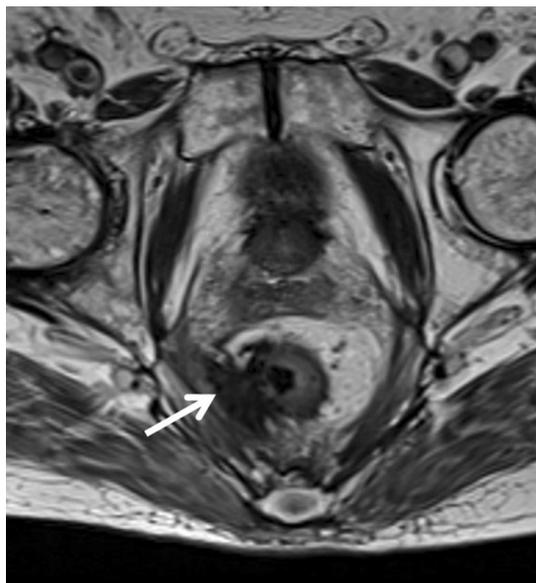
Recurrent tumor after TAMIS. A 72-year-old man. Axial T2-weighted image demonstrates an irregular mass (arrow) arising from the right posterolateral wall of the rectum 1-year following TAMIS. The mass demonstrates areas of low and intermediate signal intensity. Endoscopic biopsy confirmed a diagnosis of recurrent adenocarcinoma
